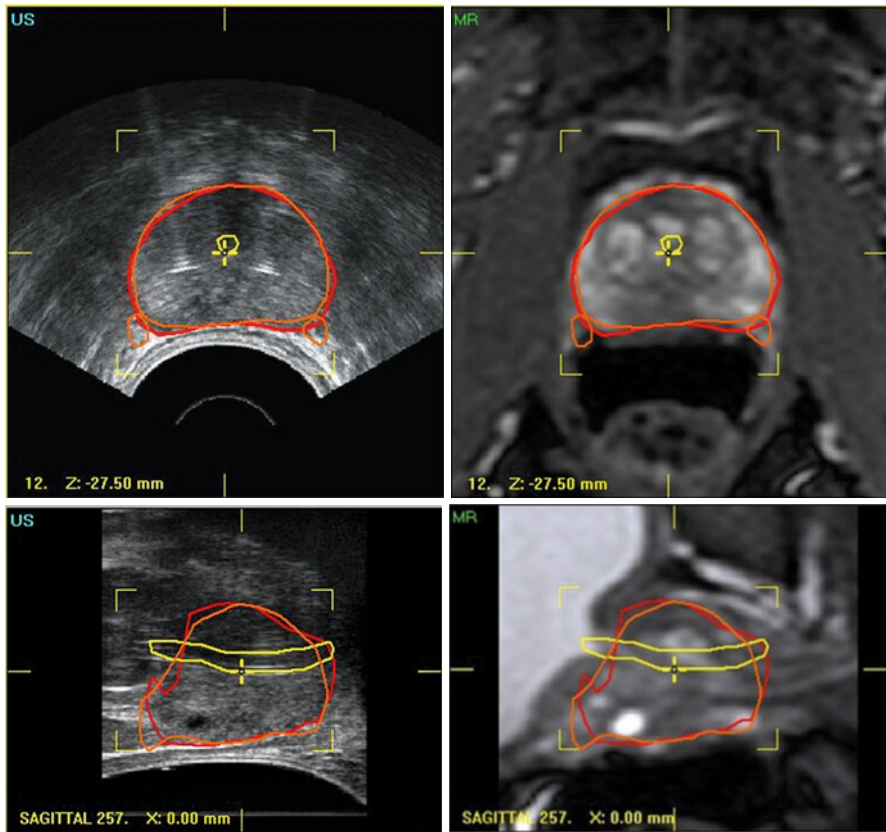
Contoured outline of the prostate in transverse and sagittal direction. The *red* line is the prostate contour using TRUS. The *orange* line is the contour outlined with MRI. With MRI the neurovascular bundle can also be depicted. *Yellow* is the outlined position of the urethra. Both the transverse and the sagittal view should be used when placing the needles. Ultrasound systems may have a revolving probe to make 3D images of the prostate. This is used to optimize the position of the needles.
